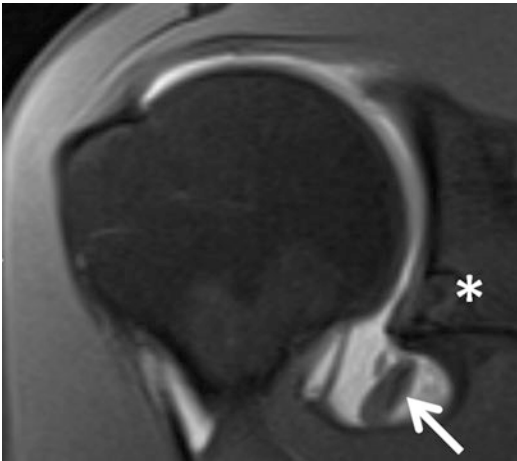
Displaced labral tear on direct MR arthrography. Coronal oblique T1-weighted fat-suppressed image from a direct MR arthrogram in a patient status post anteroinferior labral repair (asterisk identifies the suture anchor) demonstrates a hypertrophied torn labral fragment (arrow) displaced into the inferior aspect of the joint, made conspicuous by the intra-articular contrast
